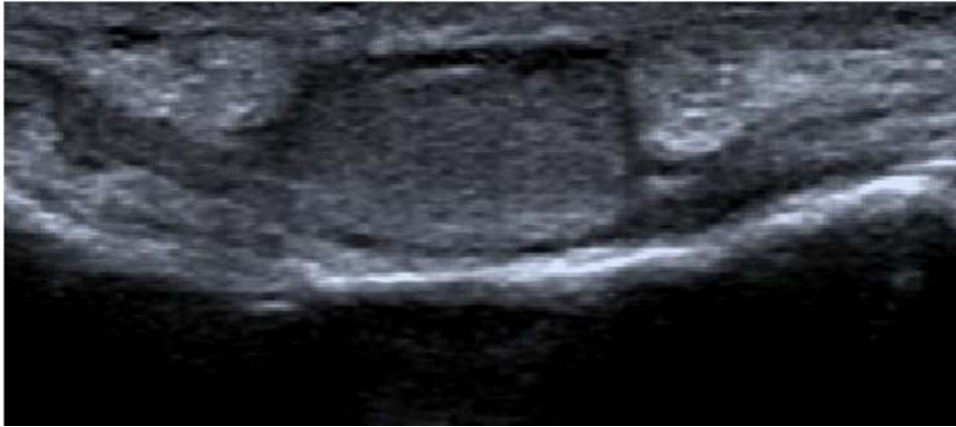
Ultrasonographic image of the first finger of a 69-year-old woman: Hypoechoic vascularized soft tissue mass around the flexor tendon that proved to be a giant cell tumour.(21)*
